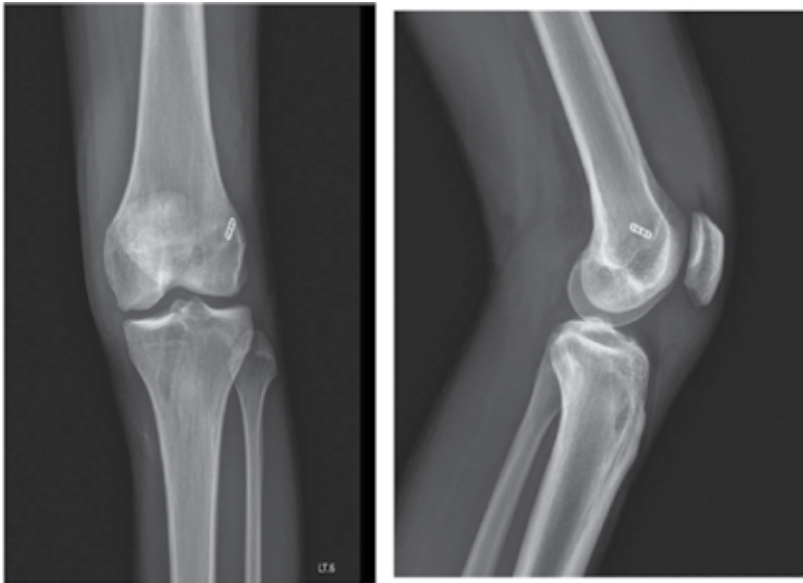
Postoperative radiographs of the left knee in anteroposterior and lateral views reveal the position of the EndoButton and the bony tunnels.
